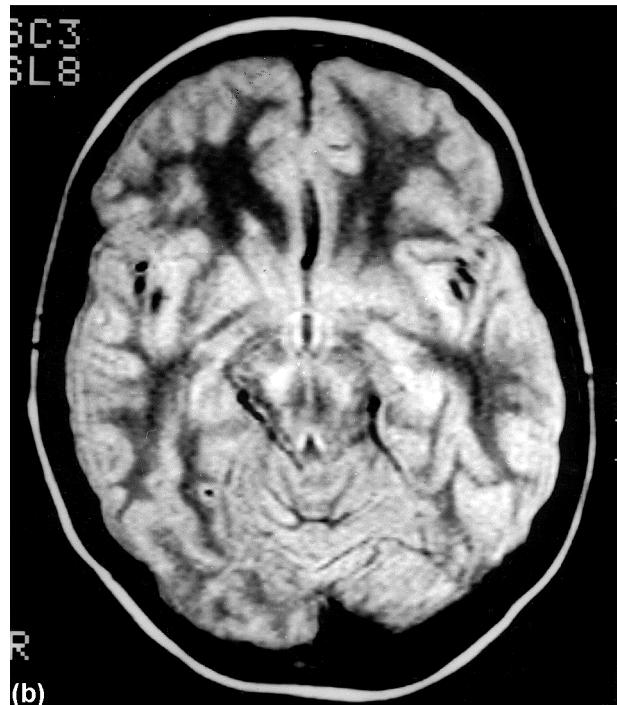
(a, b) Magnetic resonance image examination of the same patient as in Fig. 1, 1 month later. Lesions are still present, but they show a clear regression when compared with the primary examination.
